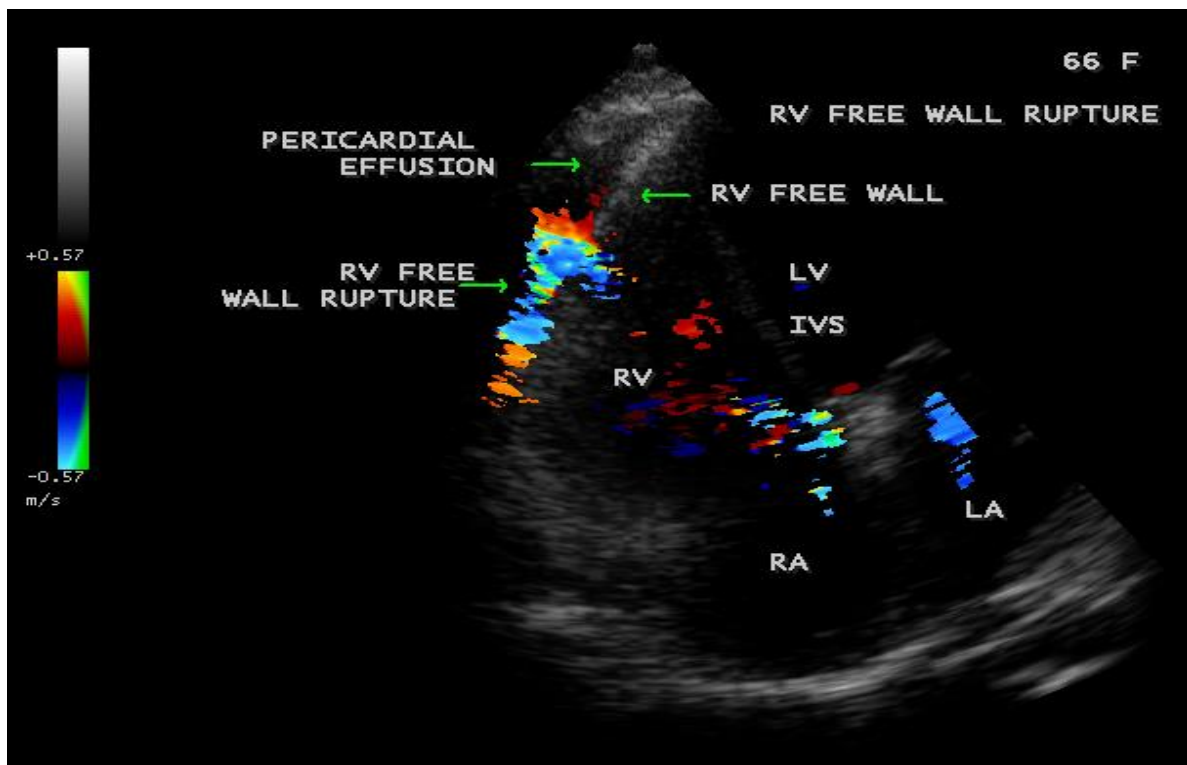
Color Doppler imaging showing the RV free wall rupture into the pericardial space with effusion in a 66-year old female with acute inferior wall infarction.
